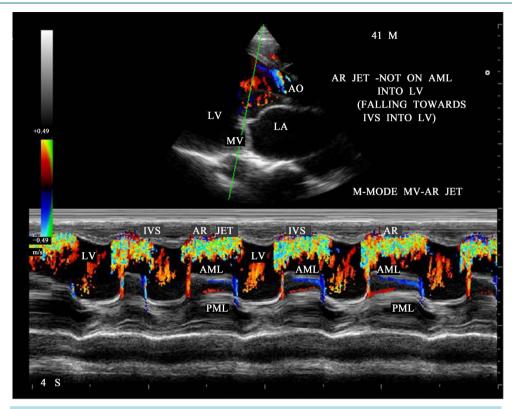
M-mode color doppler showing AR jet towards IVS (interventricular septum) at mitral valve level).
